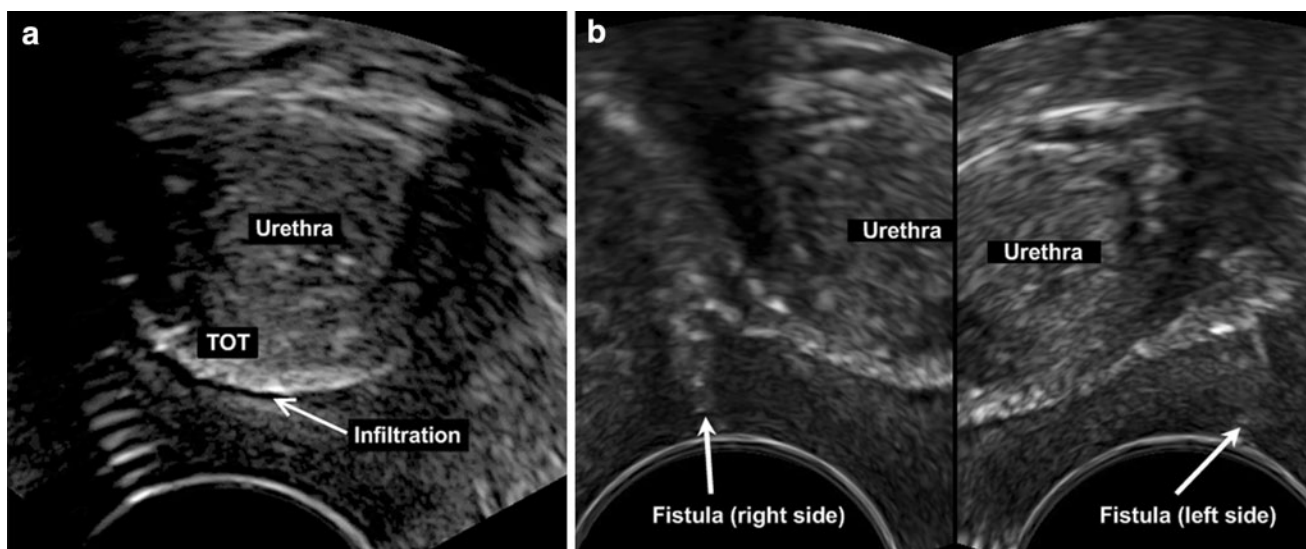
Introital ultrasound in axial view: the echogenic tape and the encompassed tissue show sonographic signs of infiltration. At rest, an anechoic fluid layer is surrounding the tape (a). By exerting pressure
